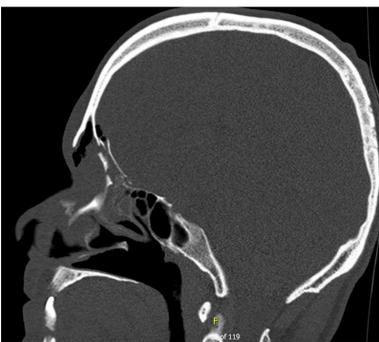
Preoperative CT demonstrating skull base and frontal sinus fractures
